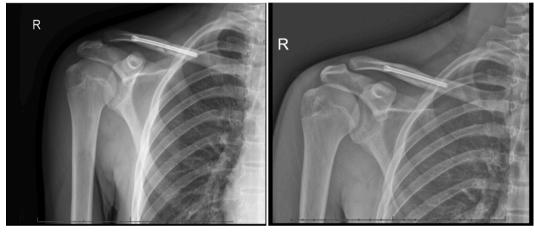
Case 1 radiographs.
